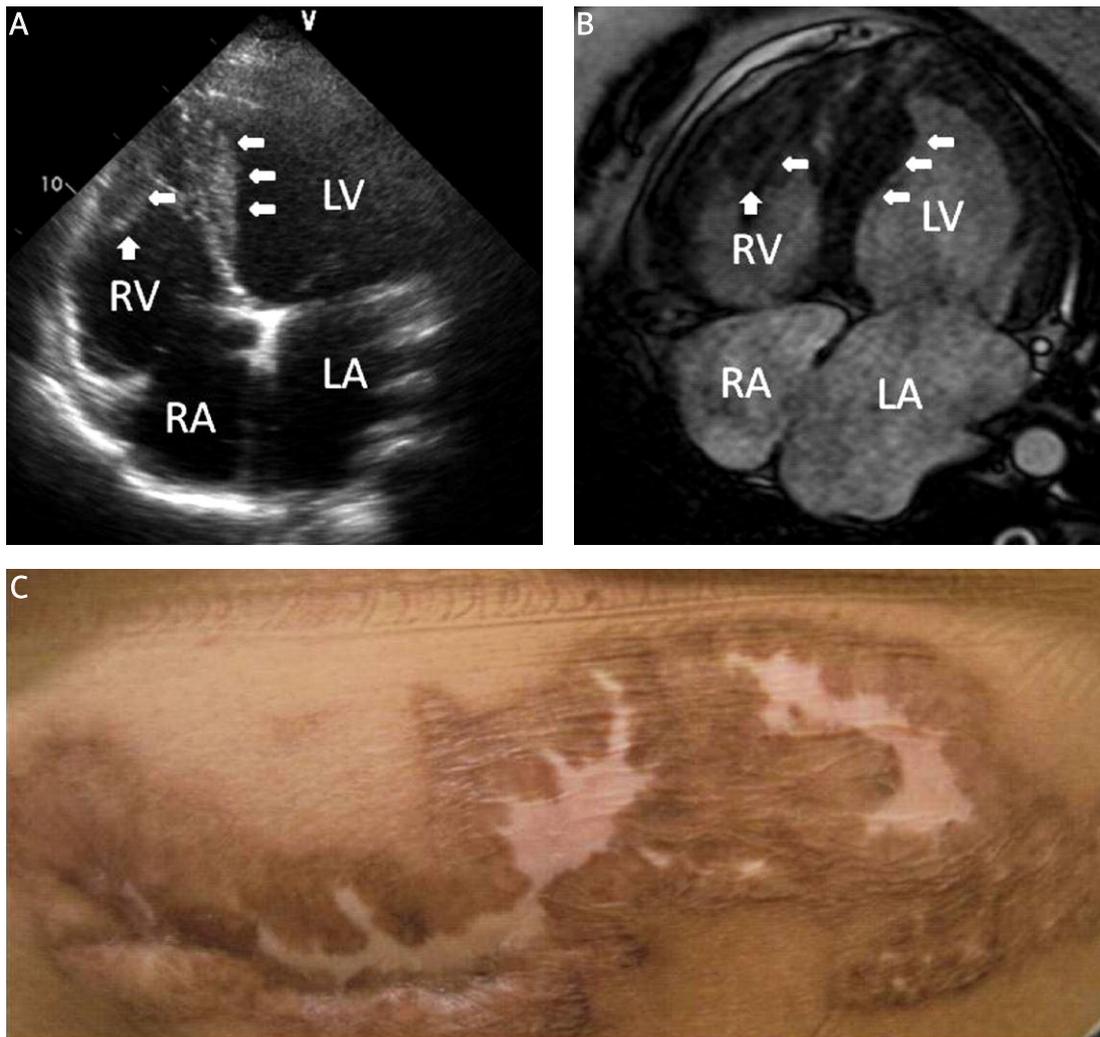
A – Echocardiogram showing multiple intracardiac thrombi (indicated by arrowheads). B – Cardiac magnetic resonance showing similar findings to echocardiogram. C – Large scar in the abdomen after the WISN healed
